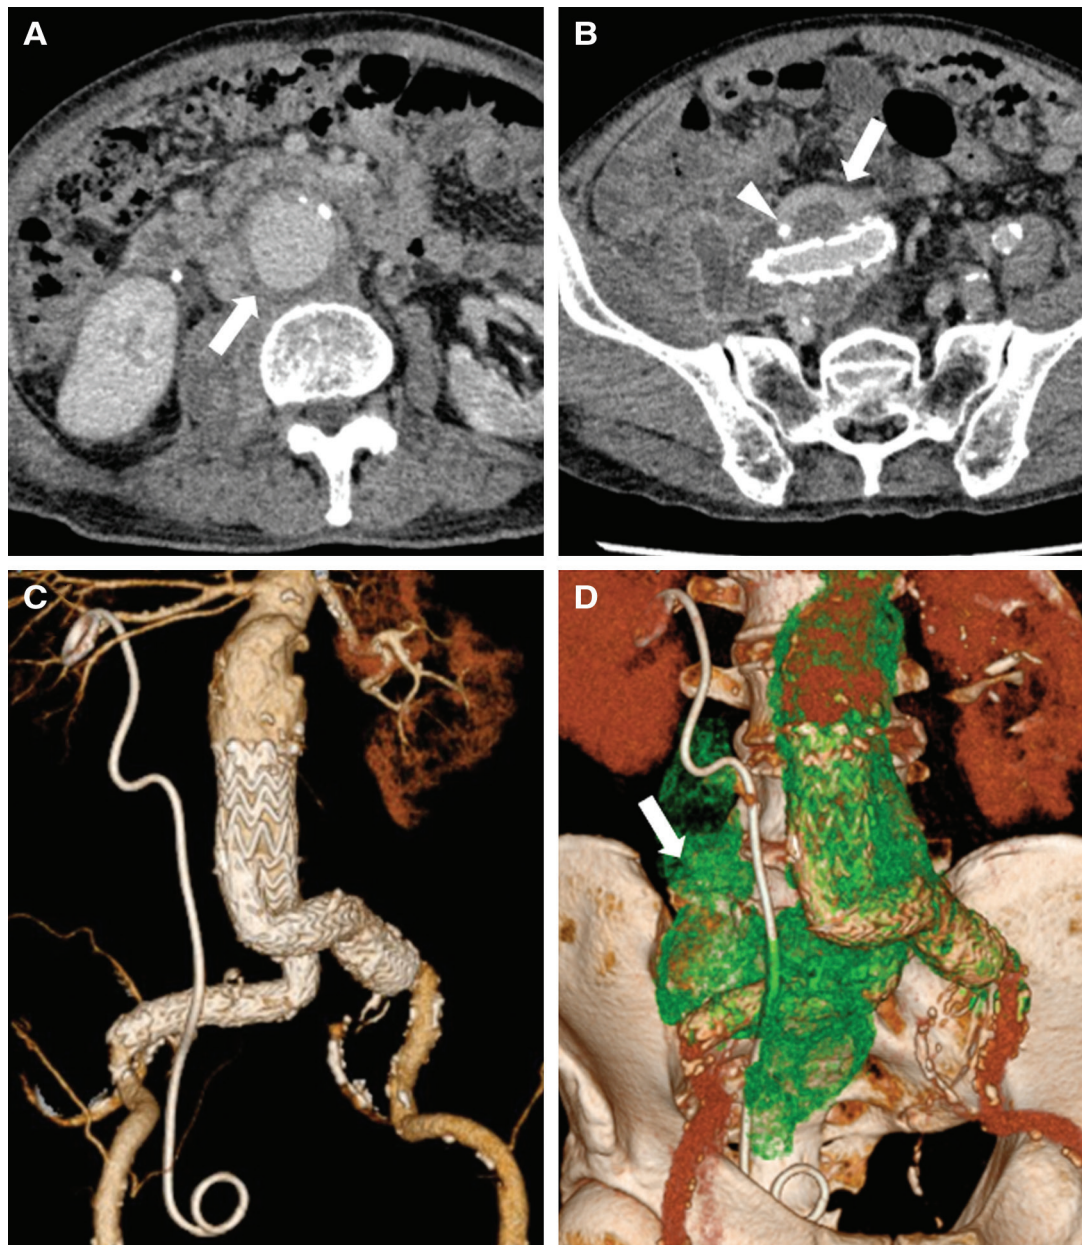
Preoperative computed tomography scans. (A) Expansion of the aneurysmal sac with surrounding tissue thickening (arrow). (B) Abscess formation around the right common iliac artery and in the right iliopsoas lesion were suspected (arrow). The right ureter was involved in the infected area around the right common iliac artery (arrow head). (C) Distally migrated endografts and ureteral stent placed in the right ureter. (D) Abscess formation around the right common iliac artery is shown in the green-colored area (arrow).
